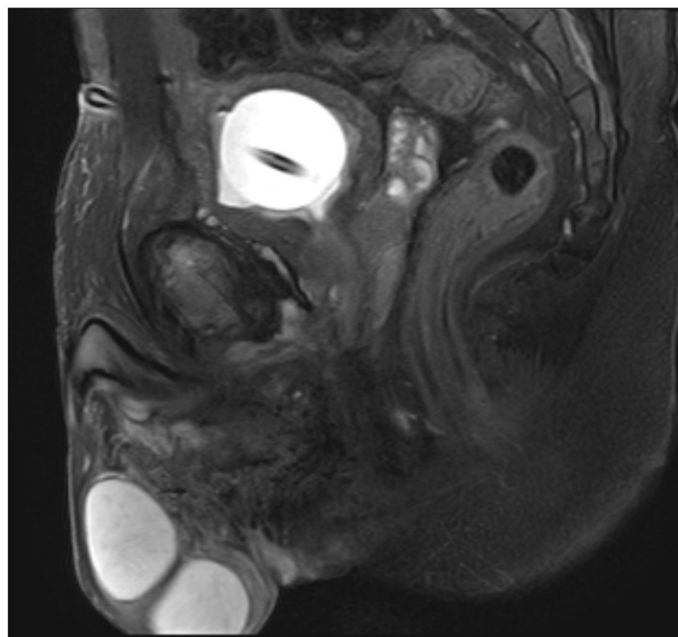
Routine magnetic resonance imaging (MRI) at the radiology department
